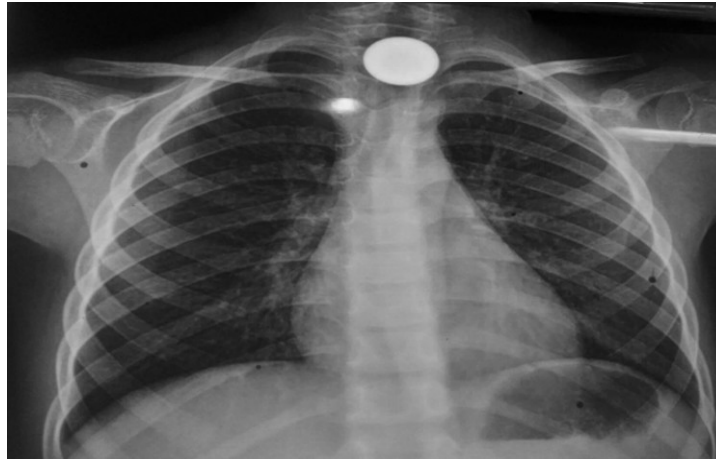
Frontal chest X-ray showing a rounded, metallic-density foreign body located at the level of the esophageal inlet.
